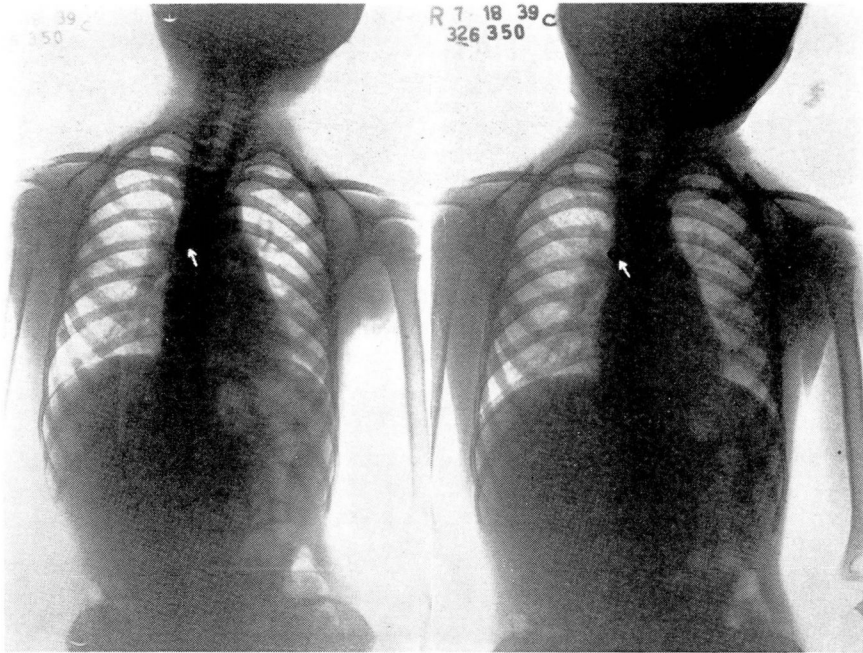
(Case 1): Roentgenogram of the chest, taken in expiration, showing typical roentgen evidence of obstructive emphysema secondary to a foreign body (metal tip of whistle).
